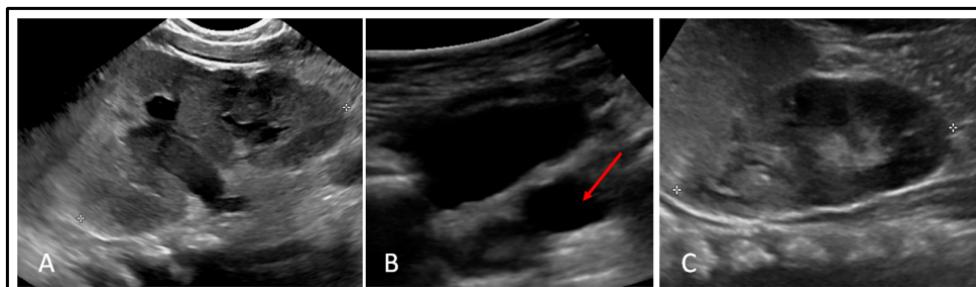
Infant presented with febrile UTI. Renal ultrasound showed duplicated collecting system with upper pole hydroureteronephrosis and mild lower pole hydronephrosis. (Panel A) At the level of the bladder, a dilated ureter (red arrow) is seen posterolateral to the bladder (Panel B) VCUG was normal. The child underwent ureterostomy of upper pole ureter with plans for an upper pole to lower pole ureteroureterostomy at a later date. Post operation renal ultrasound revealed resolution of upper pole hydronephrosis.
